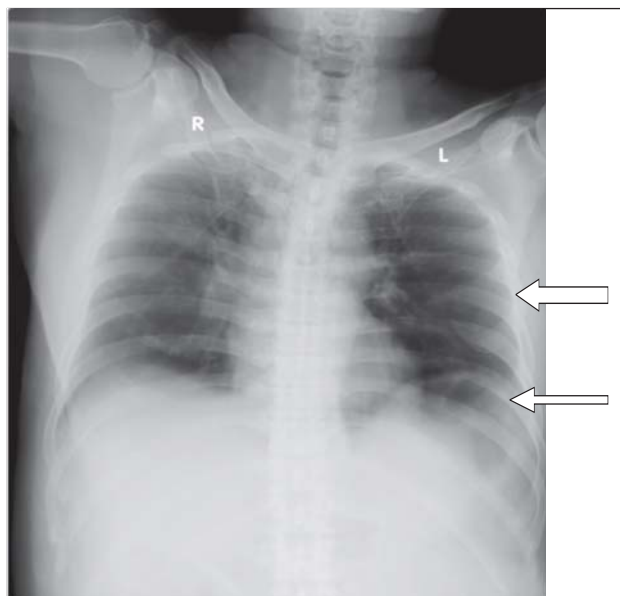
Chest X-ray of patient showing wedge shape opacity (thin arrow) at left base and prominent left pulmonary vascular markings (thick arrow) respectively.
